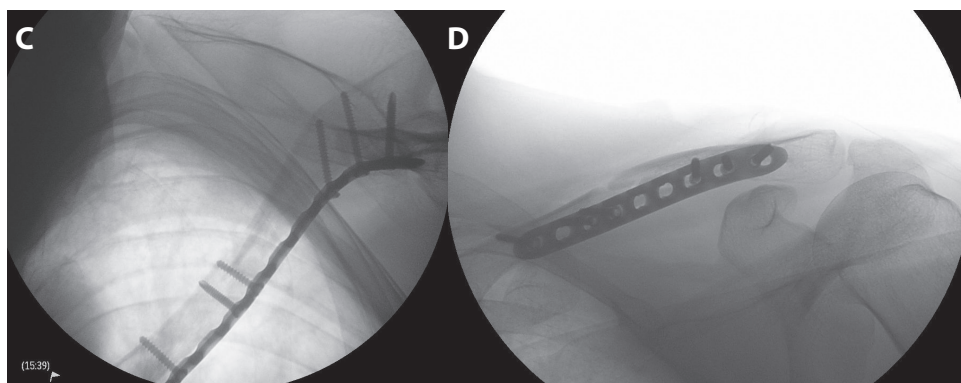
AND 3D. Intraoperative x-rays of open reduction and internal fixation with anterior placed 3.5 Locking Compression Plate (DePuy Synthes, Switzerland) in a bridging technique through a longitudinal approach.
